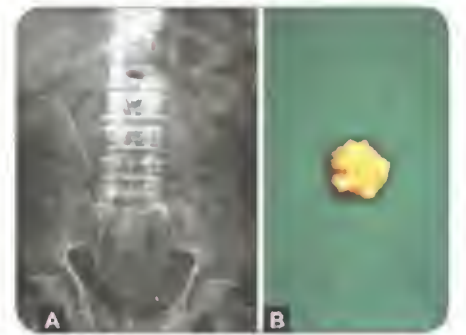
Plain X-ray abdomen showing multiple air fluid levels due to bowel obstruction.
